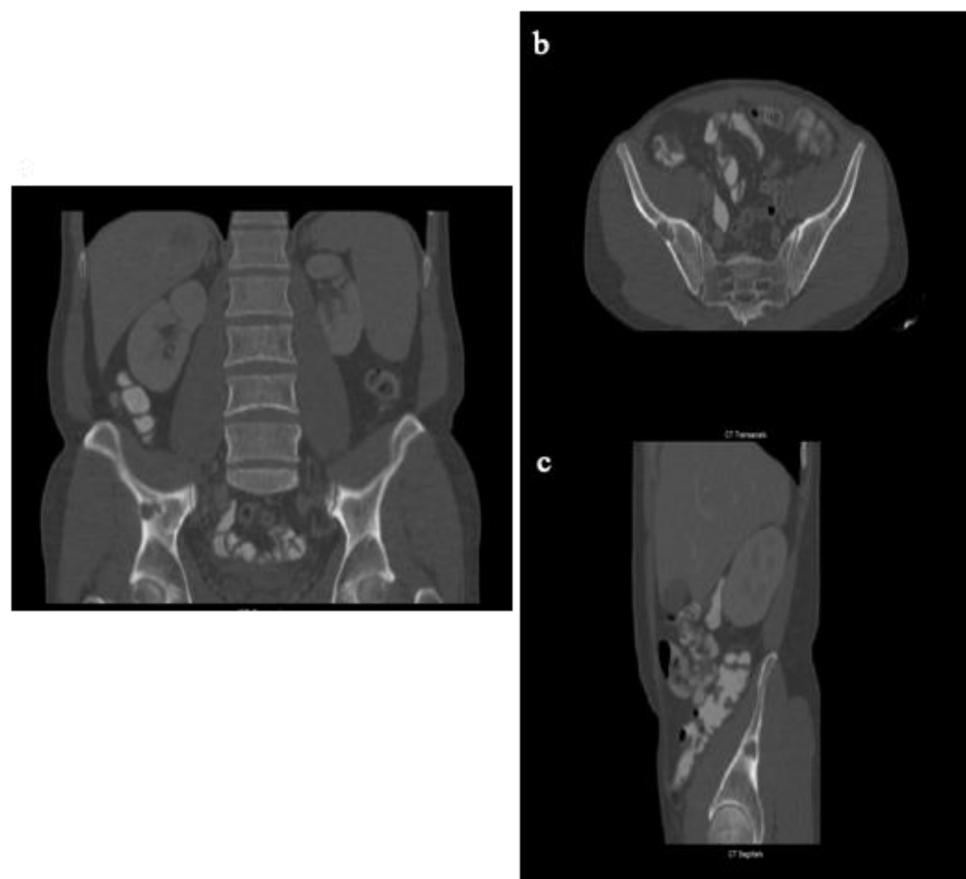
Contrast-enhanced CT at the bone window showed a lytic bone lesion without any sign of local recurrence (a: coronal,b: axial, and c: sagittal images).
